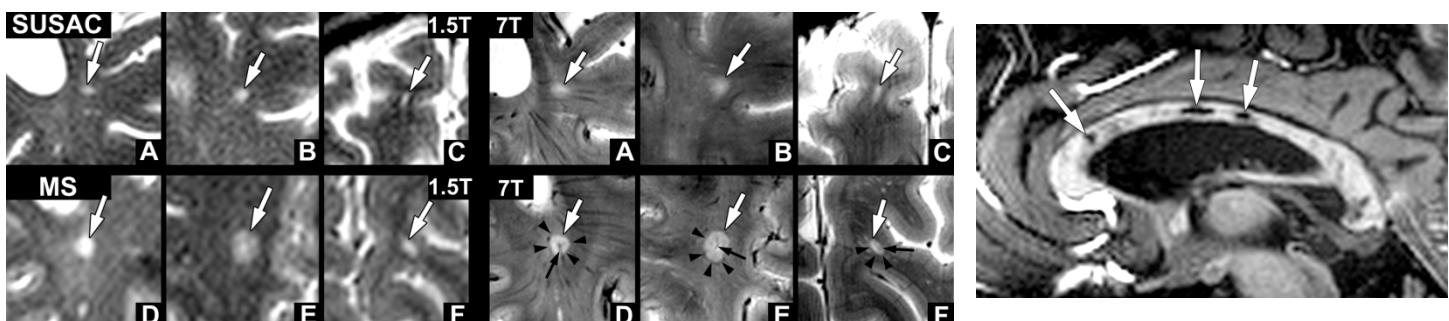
Structure of T2* white matter lesions differentiates Susac syndrome from MS: Comparison between 1.5T and 7T. At conventional MRI, white matter lesions (white arrow) in both Susac syndrome (A-C) and MS (D-F) appear as hyperintense lesions and cannot be distinguished from each other. At 7T T2* FLASH, perivenous (black arrow) MS plaques particularly express a characteristic hypointense rim (black arrow head). In contrast to their clearly centered position within MS plaques, small veins (black arrow) rarely identified in Susac syndrome lesions were most commonly located in the lesion periphery (A).
